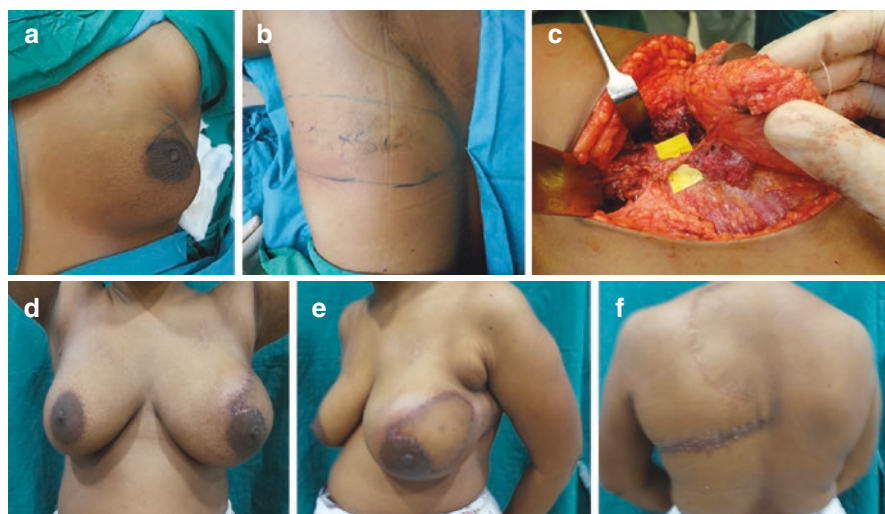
TDAP flap for UOQ defect in a case of previous spinal surgery requiring LD muscle function for using crutches, (a) Recurrent IDC with scar, (b) Flap planned guided by the doppler signal, (c) Perforator dissected sparing the nerves, (d) Healed donor site, (e and f) Follow up
